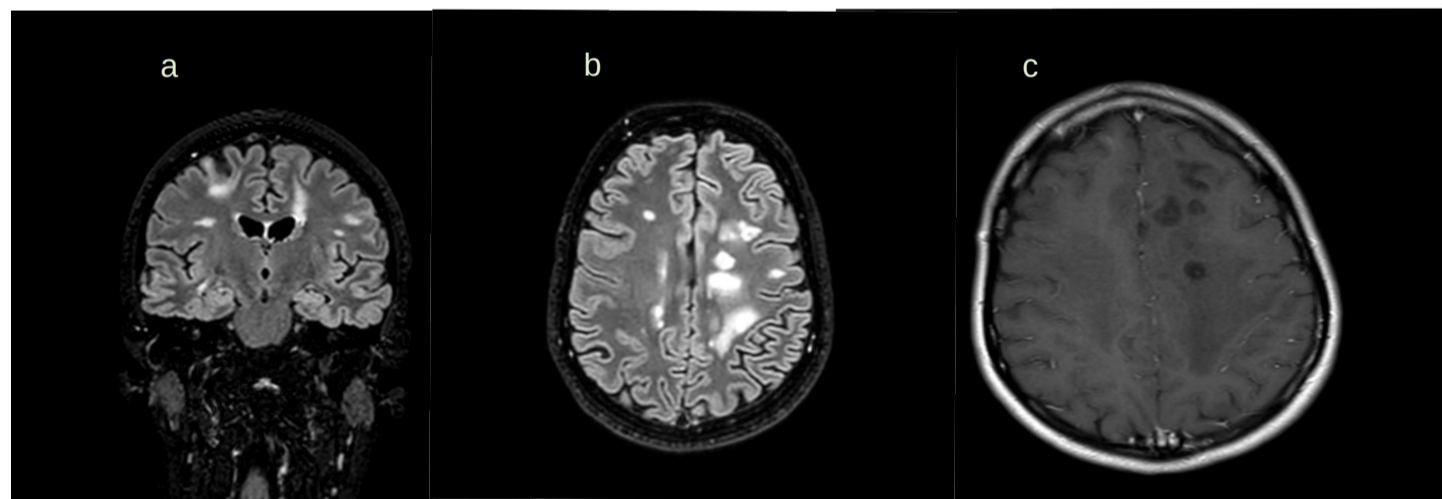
MRI at Week 3 on treatment: coronal flair (a), Axial FLAIR (b), T1, with gadolinium (c)
